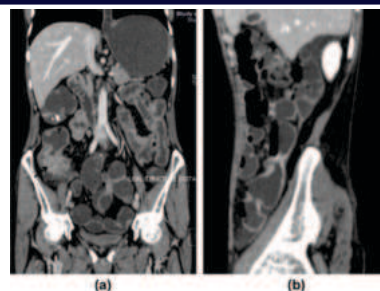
Multiple small bowel strictures with ileocaecal involvement. (a) Coronal CT image shows ileal stricture with mass-like configuration in ileocaecal region (arrow). (b) Sagittal CT image shows multiple ileal strictures with interstricture bowel dilatation.
